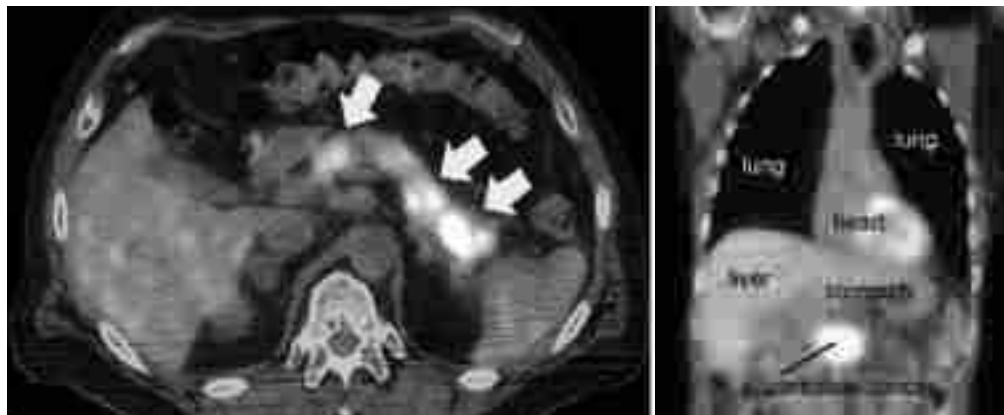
PET-CT of the pancreas
